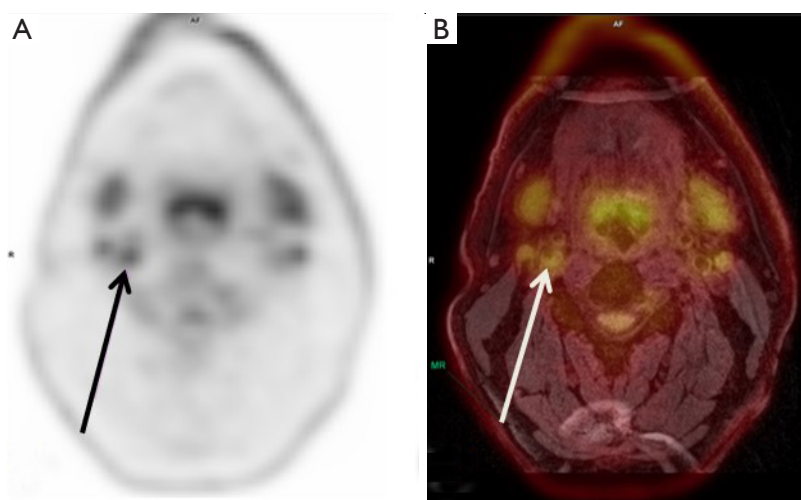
(A) ^{18}F -FDG PET image of the neck (left) of a patient with a carotid plaque; (B) a colour overlay of the PET image as displayed in (A) on the corresponding MR image. Anatomical information from MRI confirms ^{18}F FDG uptake in the symptomatic carotid plaque (arrow), while hardly any uptake is shown in the contralateral asymptomatic carotid artery.
